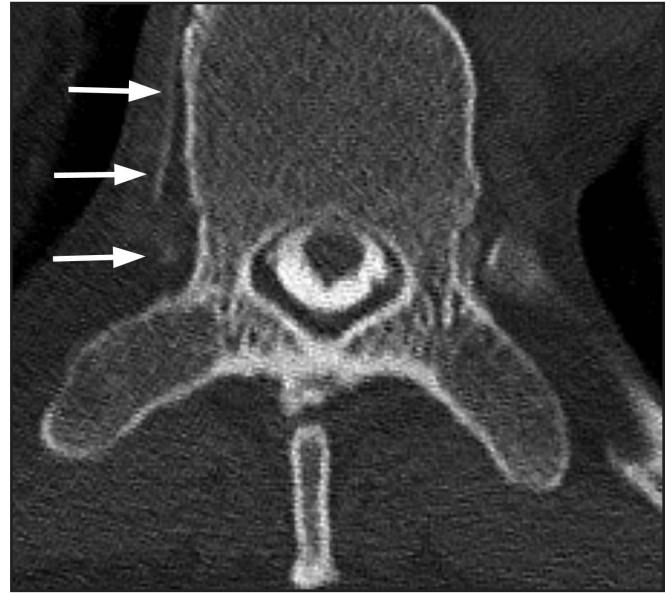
Dynamic CT myelogram demonstrating contrast in a presumed epidural vein (arrows) indicative of a CSF-venous fistula.
